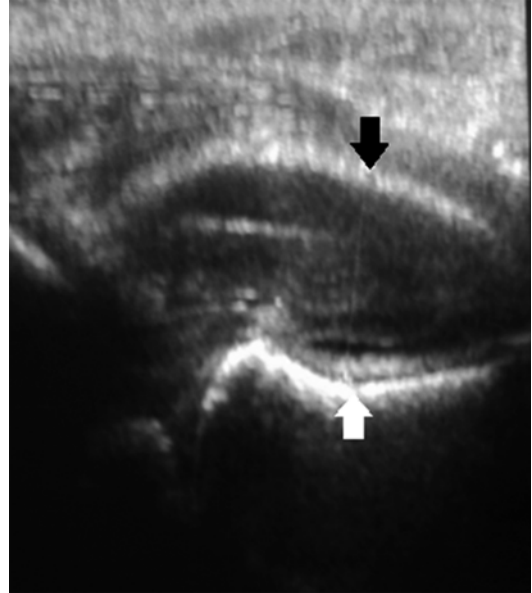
Ultrasound of the hip showing a large effusion. The child was well and had a transient synovitis. The *white arrow* indicates the anterior aspect of the metaphysis, and the *black arrow* the anterior margin of the distended hip capsule
